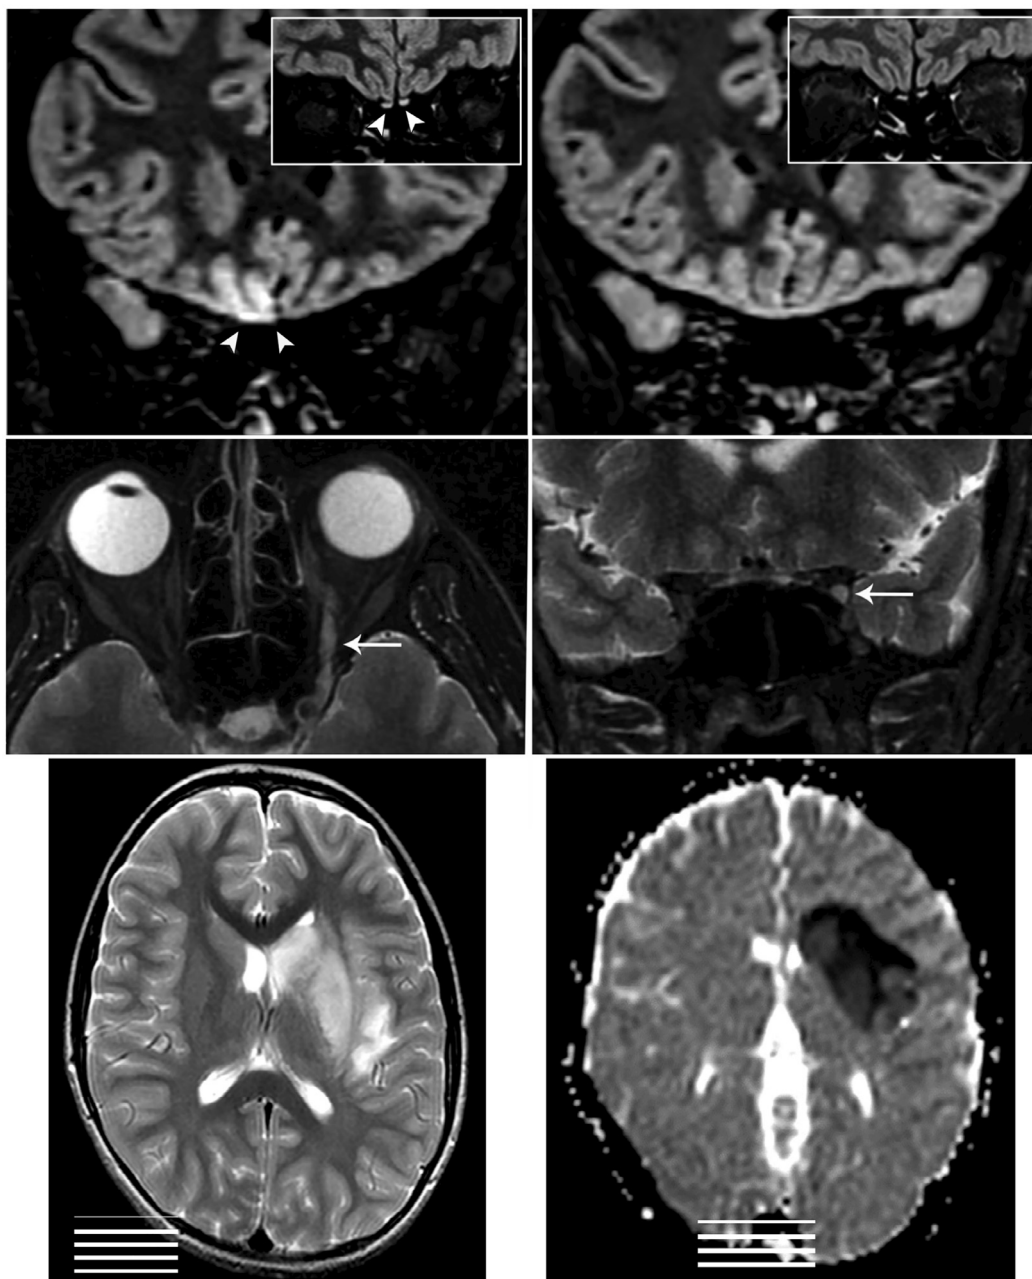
Neuroimaging findings in patients with mild COVID-19 infection. (a) Coronal T2 FLAIR view of a cortical hyperintensity in the right gyrus rectus (yellow arrowheads) and subtle hyperintensities in the bilateral olfactory bulbs (inset, white arrowheads) of a 25-year-old woman with anosmia and PCR-confirmed SARS-CoV-2 infection; (b) 28 days later, the cortical hyperintensity is completely resolved with slight reductions in the intensity and thickness of the olfactory bulbs (28). Axial (c) and coronal (d) T2-weighted fat-suppressed images depicting an enlarged CN III and increased signal of the cavernous sinus-exiting nerve in a 36-year-old man (37). Axial T2-weighted MRI (e) and apparent diffusion coefficient (ADC) map (f) depicting an acute ischemic stroke in the left basal ganglia and insula, likely from focal arterial vasculopathy, in a previously healthy SARS-CoV-2-positive 12-year-old boy with seizures, right hemiparesis, and dysarthria but no respiratory symptoms or chest CT findings (24). Panels a and b reproduced from Politi et al. (28) with permission from American Medical Association, panels c and d reproduced from Lantos et al. (37) with permission from the American Society of Neuroradiology. Panels e and f reproduced from Mirzaee et al. (24) with permission from the Radiological Society of North America (COVID-19 PMC Open Access Subset).
